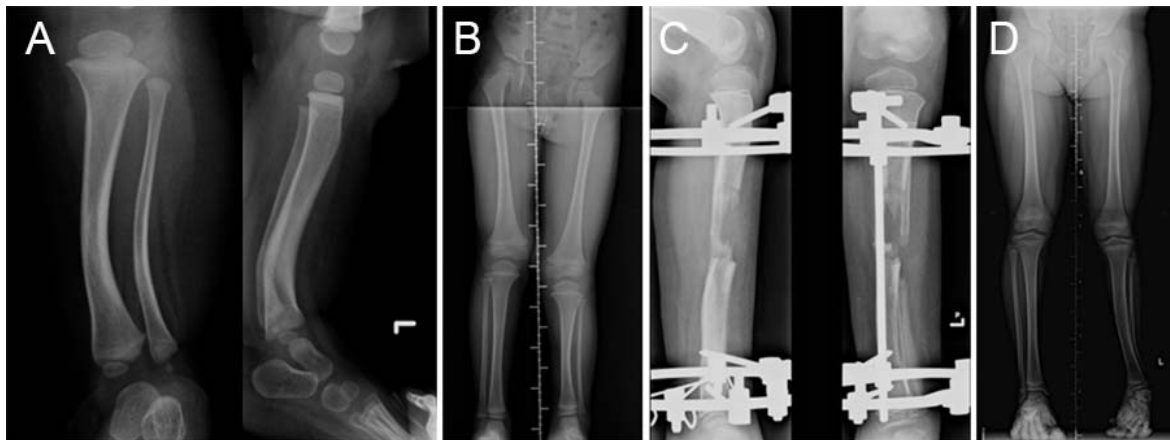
(A) radiographs of patient at the age of 3 years showed posteromedial angulation, (B) remodeling of angulation was shown with LLD 2.5 cm at 4 years of age, (C) Ilizarov lengthening was performed, (D) final result at the age of 11 years.
